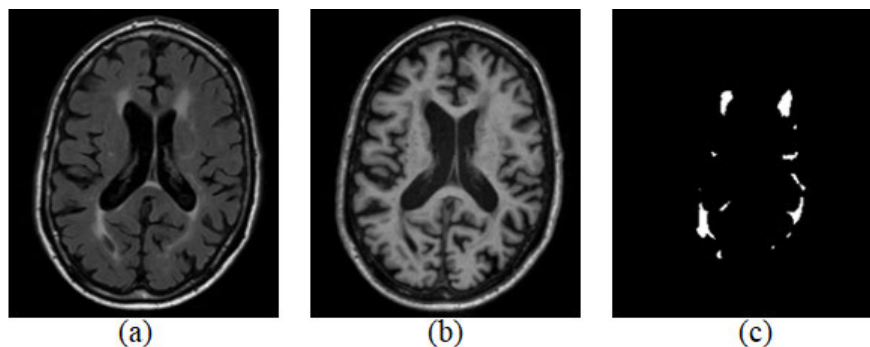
A sample of MRI slice from FLAIR modality (a), T1 modality (b) and its corresponding manual annotation of WMH by a neuroradiologist (c).
